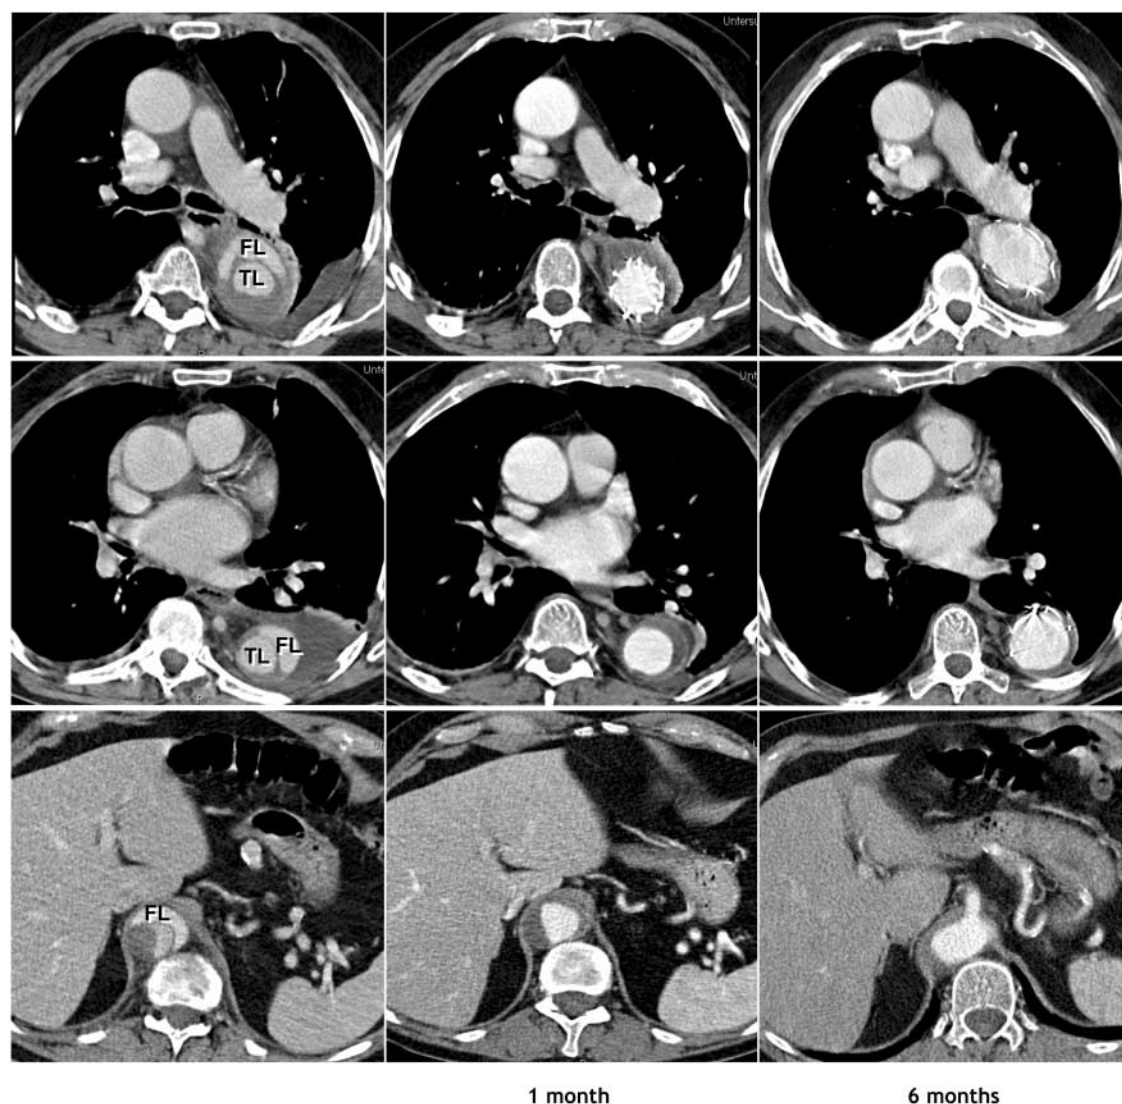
Pre-interventional contrast-enhanced CT and comparable CT scans 1 month and 6 months following thoracic endovascular stent-graft placement demonstrating complete obliteration and resolution of the FL and enlargement of the TL of the entire thoracic aorta down to the level of the abdominal aorta (aortic remodelling).
